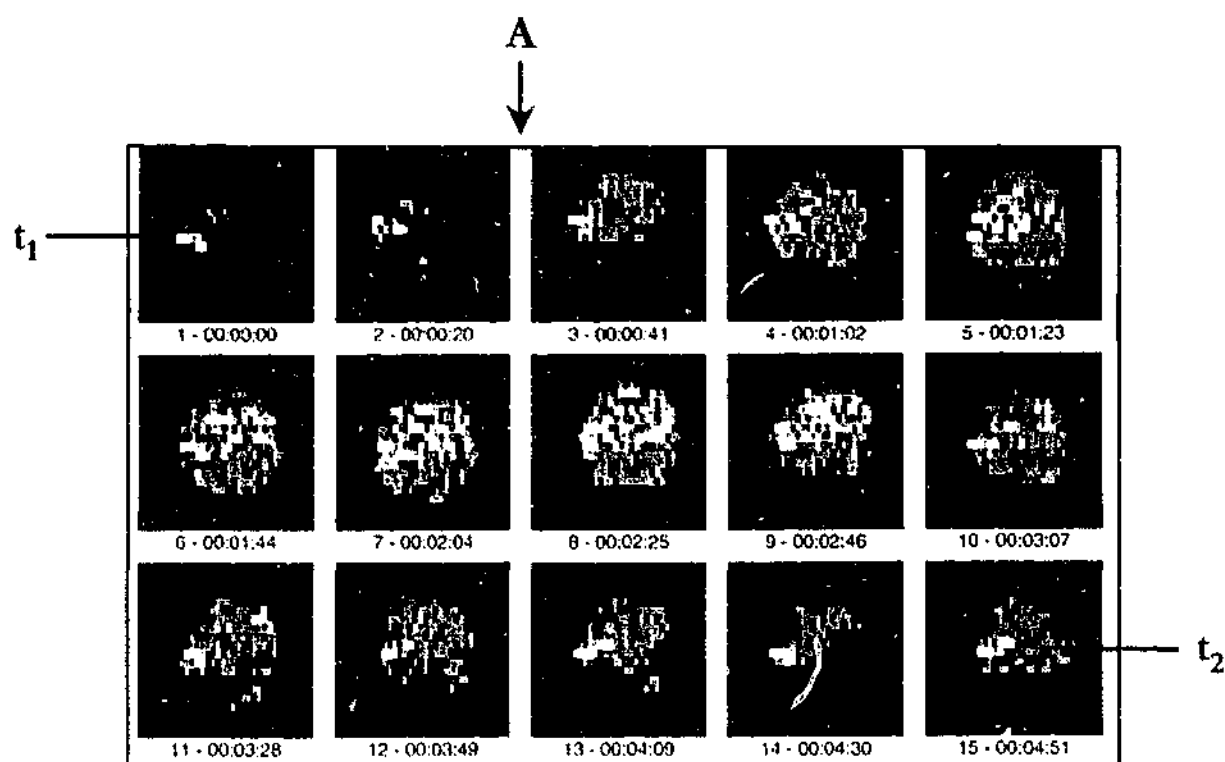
Blood Perfusion as Measured by the Laser Doppler Flowmeter
